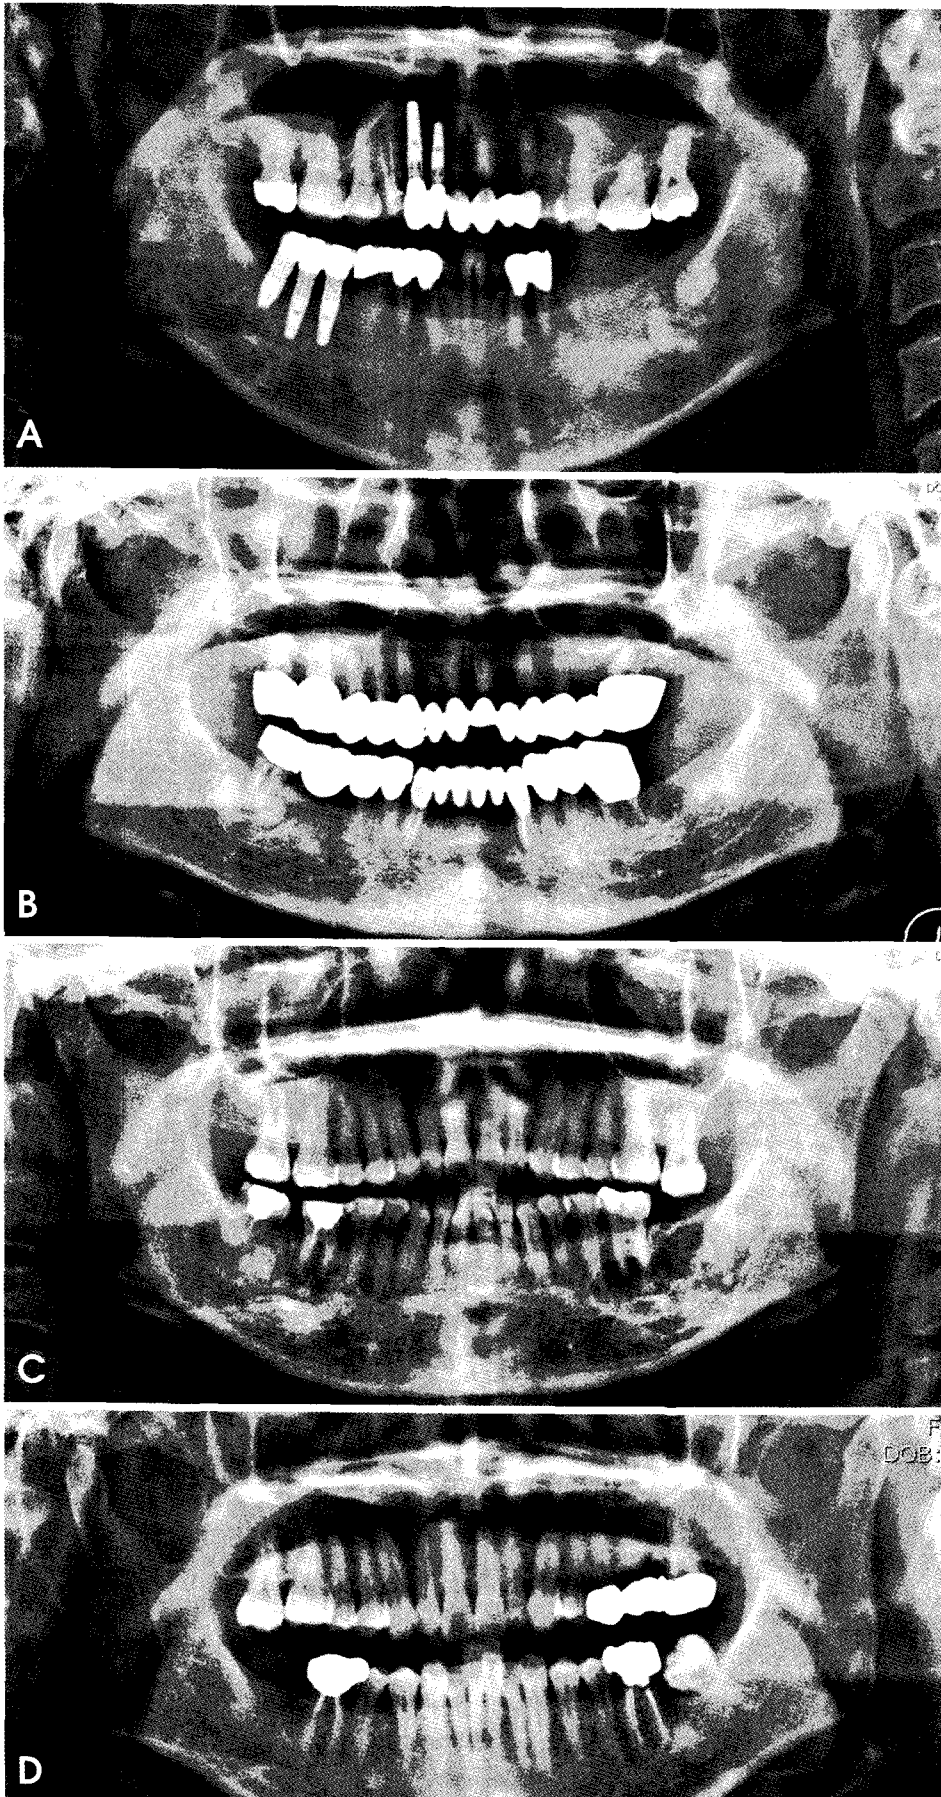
A, Unilateral FCOD appearing as multiple radiopaque masses in the left mandibular edentulous molar area. B, Bilateral FCOD showing calcified masses with radiolucent rims in both posterior mandibular areas. C, Bi-maxillary lobulated FCOD presenting as mixed lesions in both maxillary and mandibular regions. D, Focal COD appearing as periapical radiopacity of the left first mandibular molar.
